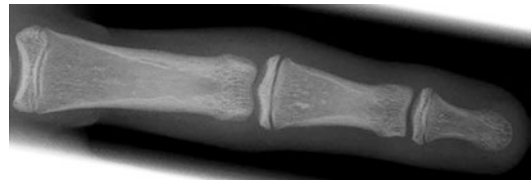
X-ray in a.p. projection: soft tissue swelling over the PIP joint without clear evidence of fracture
